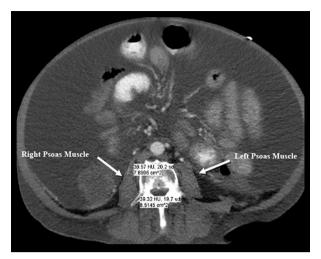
CT abdomen/pelvis at L4 vertebral level demonstrating patient total psoas area. The mean cross-sectional area of the left and right psoas muscle at the level of the fourth lumbar vertebra (L4) was determined. This was accomplished by first identifying the individual vertebral levels on a CT scan of the abdomen and pelvis. We then selected the individual imaging slice at the mid-portion of the L4 vertebra and outlined the borders of the left and right psoas muscle. The crosssectional area (in mm<sup>2</sup>) of the enclosed regions was used to calculate the mean total psoas muscle area (TPA).
